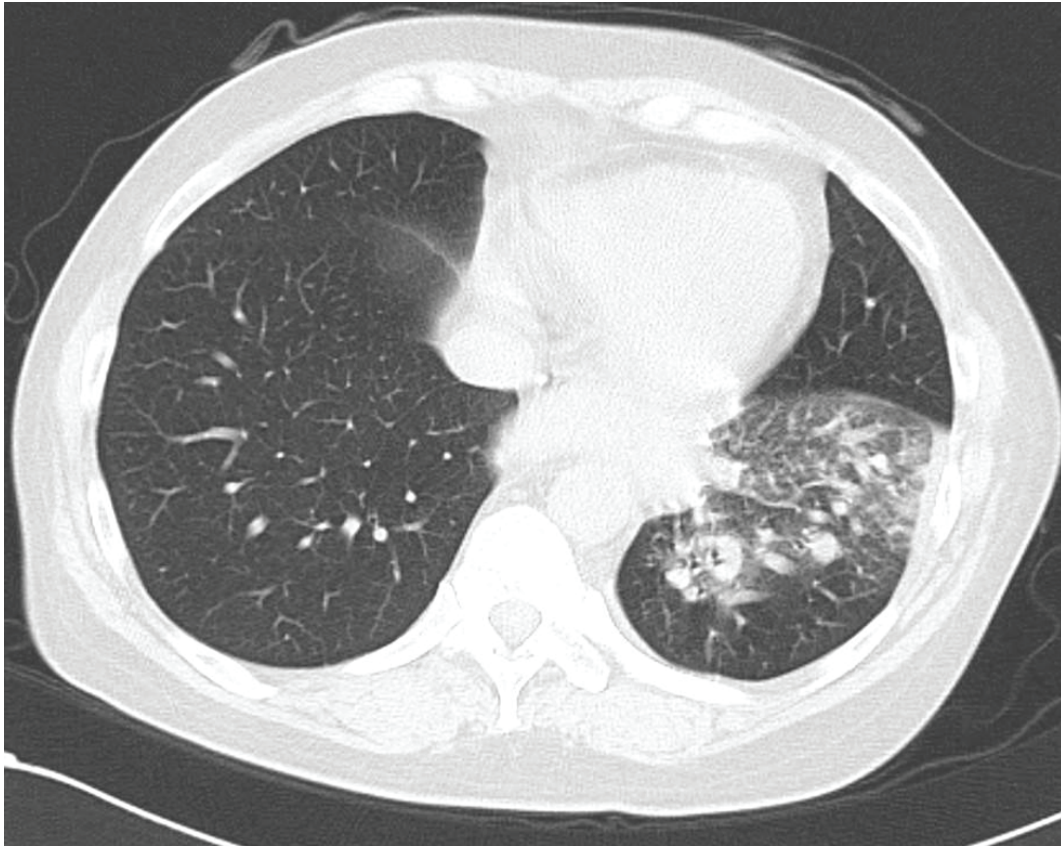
A chest CT shows an arterial branch from the abdominal aorta to the basal segment of the left-lower lobe (arrow).
